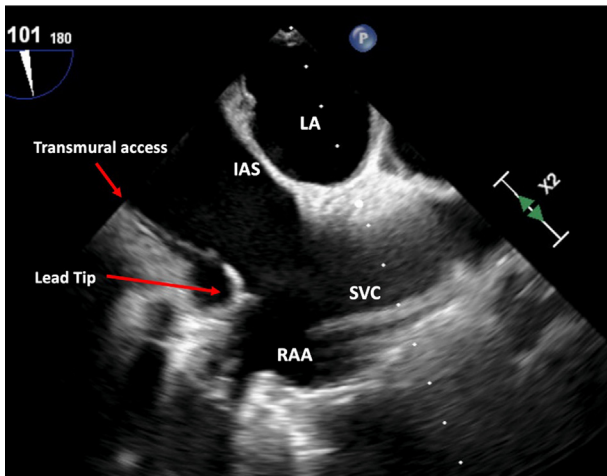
Transesophageal echocardiographic imaging used to guide transmural implantation of a Medtronic 5076 transvenous pacing lead to the base of the resected right atrial appendage in a patient after surgery for adult congenital heart disease with an open chest. IAS, Interatrial septum; LA, left atrium; RAA, right atrial appendage; SVC, superior vena cava.
